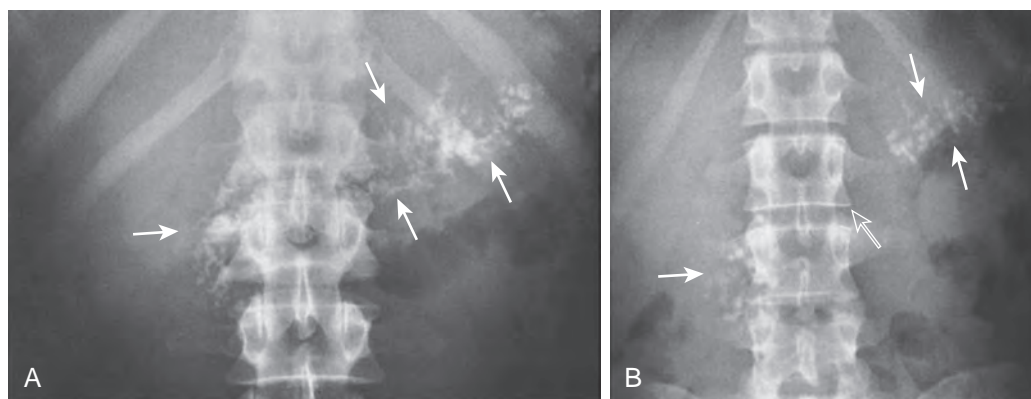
Pancreatic calcifications on plain abdominal radiographs. A. The entire gland contains numerous small calcifications located in the main pancreatic duct and its radicles (arrows). B. Pancreatic calcifications are located in the head and tail of the pancreas (solid arrows). The lack of calcifications in the body of the pancreas (open arrow) was due to displacement by a pancreatic pseudocyst.
